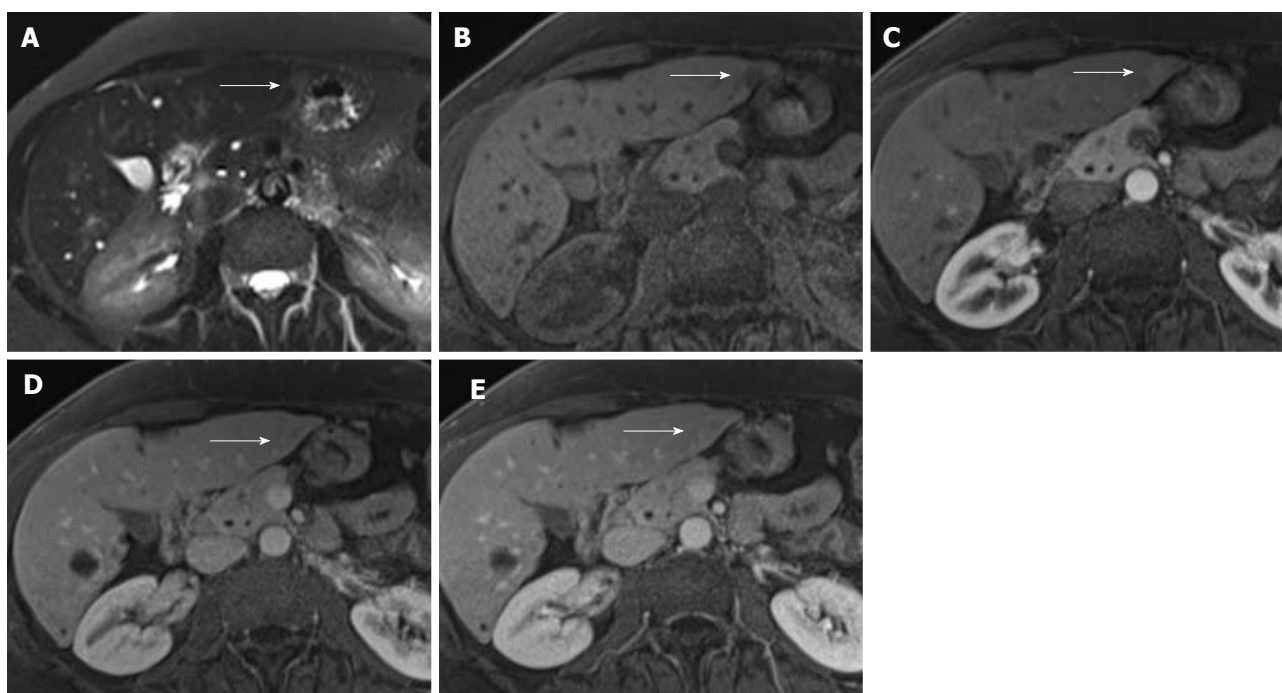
Imaging findings of case 2. A: T2-weighted fat-saturated image showing subtle focal mass (indicated by arrow) in subcapsular portion of segment 2 with increased signal intensity as compared to background liver; B: T1-weighted fat-saturated image showing small focal mass with decreased signal intensity as compared to background liver; C: T1-weighted fat-saturated image after contrast infusion in the late arterial phase. The mass shows subtle hypervascular enhancement on this phase; D: T1-weighted fat-saturated image after contrast infusion in the portal venous phase. The mass shows faint wash-out on this phase; E: T1-weighted fat-saturated image after contrast infusion in 3 min delayed post contrast phase. The mass shows faint filling in.
